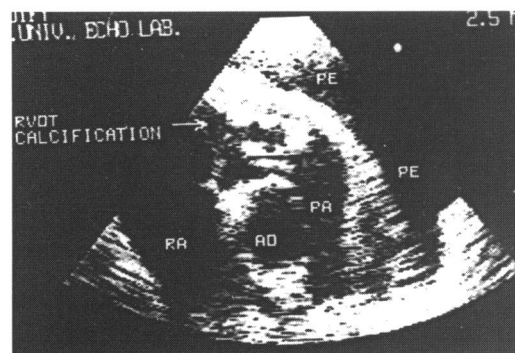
Cross sectional echocardiogram of parasternal short axis view in patient in case 11 showing endocardial thickening and calcification (arrow) of the right ventricular outflow tract (RVOT), (RA, right atrium; PA, pulmonary artery; AO, aorta; PE, pericardial effusion).
